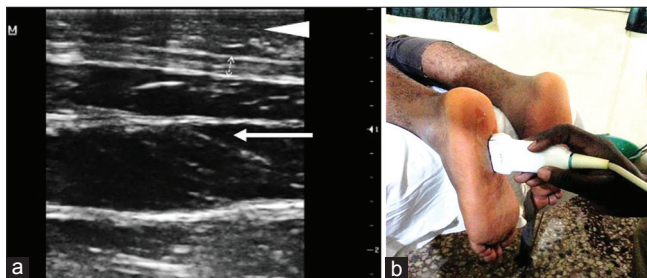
(a) Patient and probe positioning for measuring the plantar fascia thickness; (b) Corresponding sonographic image of the plantar fascia (long-axis view) showing the plantar fat tissue (arrowhead), plantar fascia (between cursors), and plantar muscles (arrow)
